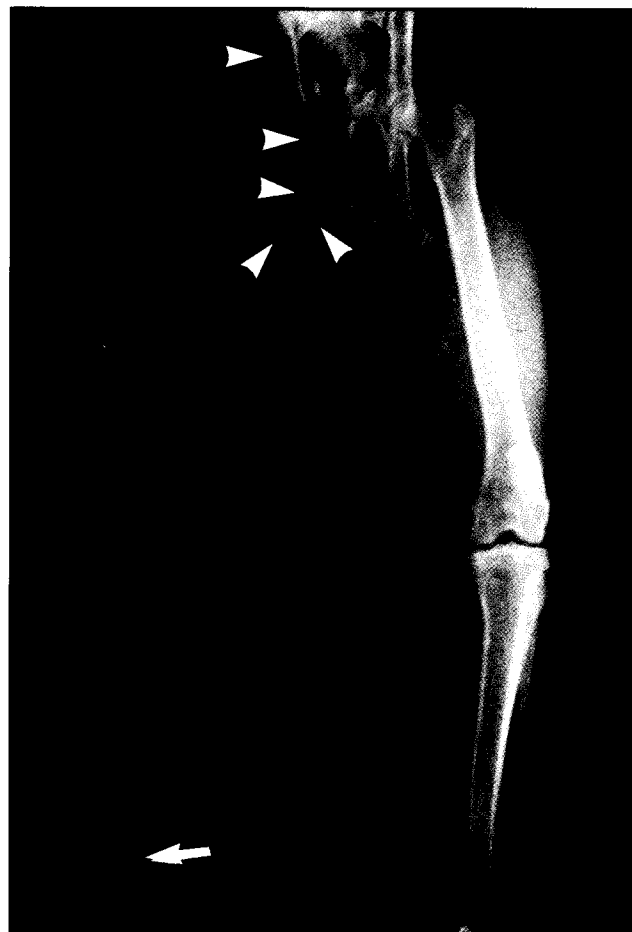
Ventrodorsal radiograph of pelvis and pelvic limbs. Note narrowing of the pelvic canal due to malunion fractures of the ilium, ischium, and pubis (arrow heads), disuse osteoporosis of the left pelvic limb and tibiotarsal luxation (arrow at bottom).
